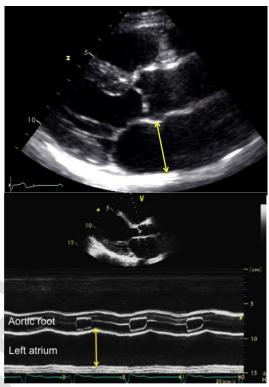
Example of an M-mode in the parasternal long axis (left: left ventricle; right: aorta/left atrium)
